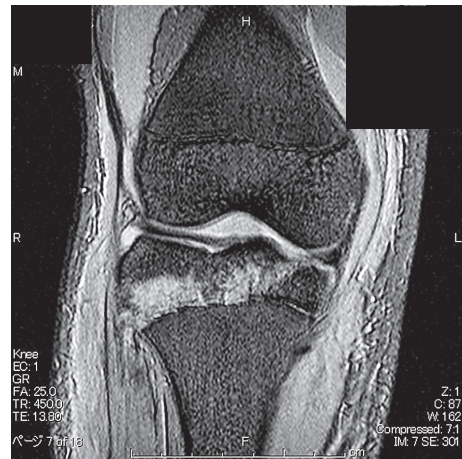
MRI of the right knee joint on the day of the injury. A high-intensity area was detected in the medial meniscus.
